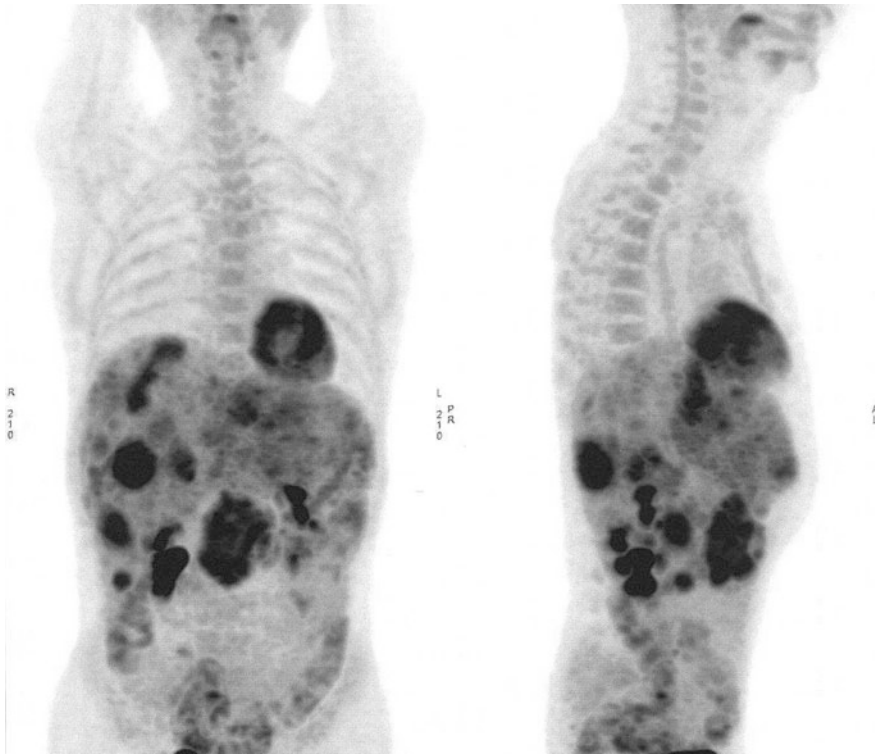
Patient with well-differentiated neuroendocrine tumors grade 2 (KI 67: 15 %). ^{18}F FDG-PET-CT showed liver metastases and mesenteric lymph node
